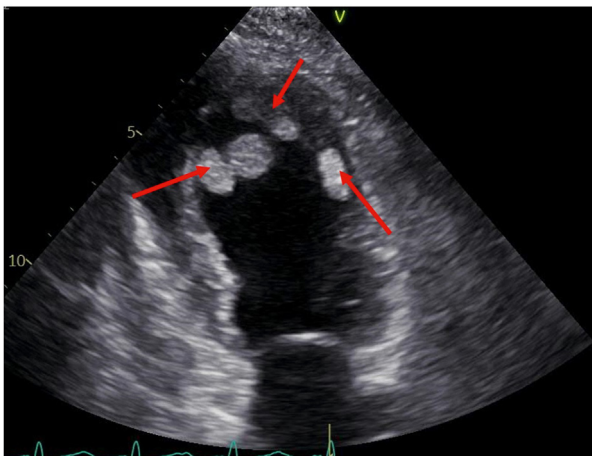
Transthoracic echocardiogram (apical two chamber view) showing left ventricular masses (arrows).
